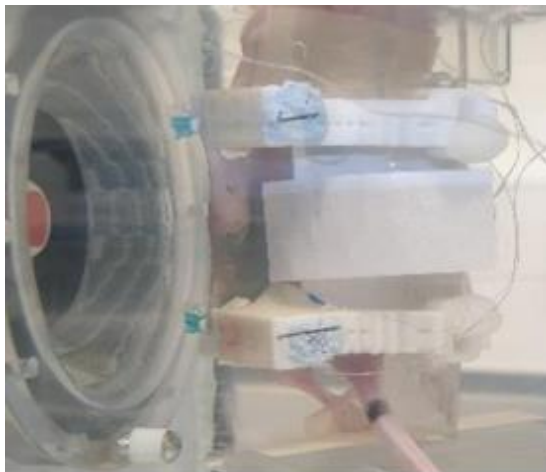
Ultrasound imaging guided therapy ultrasound system with 9-foci transparent lens used for *in vivo* delivery of hyperthermia to U87 subcutaneous tumours.
